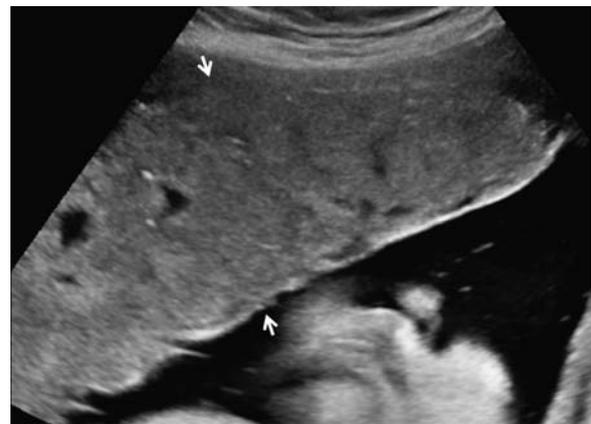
Placentomegaly seen at 34-week gestation in a diabetic mother with fetal macrosomia. Transverse gray scale ultrasound image shows a thickened placenta (arrows), [Rev 3, com 9] which measured 6 cm (>4 cm).
